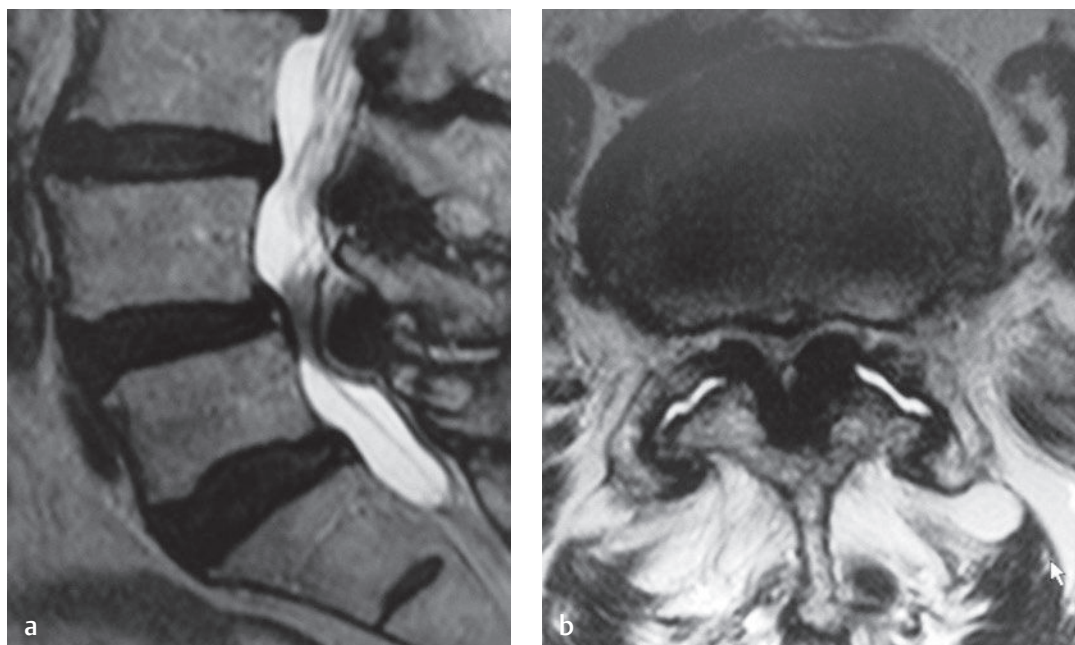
Degenerative spondylolisthesis. (a) A sagittal T2-weighted image shows Meyerding grade-1 spondylolisthesis at the L4-L5 level with severe stenosis and evidence of a high-intensity zone at the posterior annulus of the L4-L5 disc. (b) An axial T2-weighted image shows severe stenosis from a central disc bulge, ligamentum flavum hypertrophy, and facet arthropathy.[†]
